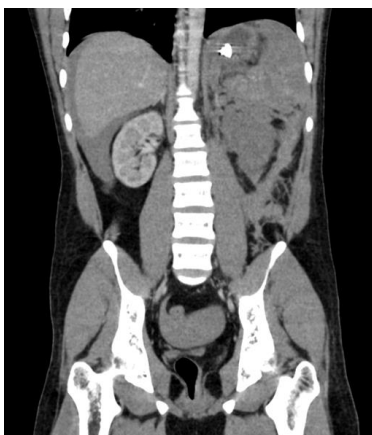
A 19-year-old female with a motor vehicle accident. Coronal CT scan image shows completely shattered spleen (grade V). Also noted is multiple left renal contusions & lacerations and gross hemoperitoneum. The patient had left 10th, 11th & 12th rib fractures. The patient underwent splenectomy.
